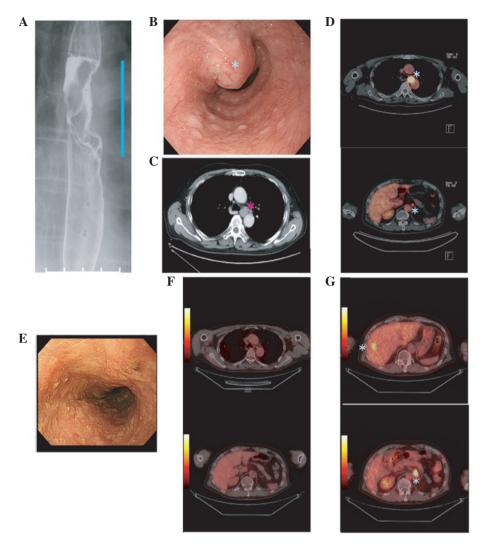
A 66-year-old male. (A-D) pretreatment, (E-G) posttreatment. (A) A type 2 tumor with a deep central ulceration 4.5 cm in length was present in the middle of the esophagus as shown by the esophagogram. (B) Gastrointestinal endoscopy revealed that the type 2 tumor occupied half of the circumference of the esophagus. (C) A CT scan of the chest and abdomen revealed a 4.5-cm lesion in which wall thickening was present concomitant with enlarged lymph nodes. (D) PET-CT revealed FDG accumulation in the primary lesion and multiple lymph nodes around the mediastinal locoregional lesion and the celiac artery at diagnosis. (E) Endoscopy revealed no residual tumor after treatment with IP chemotherapy. (F) PET-CT demonstrated complete radiological remission of the esophageal tumor and lymph nodes after 3 months of chemotherapy. (G) After 3 courses of AMR chemotherapy, PET-CT revealed liver and lymph node metastasis. CT, computed tomography; PET, positron emission tomography; FDG, fluorodeoxyglucose; AMR, amrubicin.
